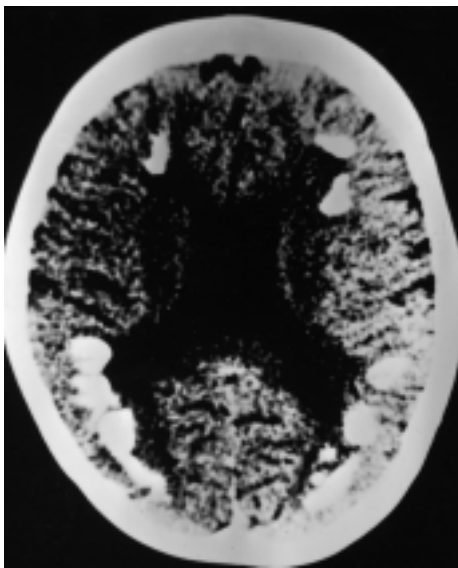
S.I., 5.5 yrs.; Brain CT-scan shows intracranial calcifications in the periventricular white matter.
